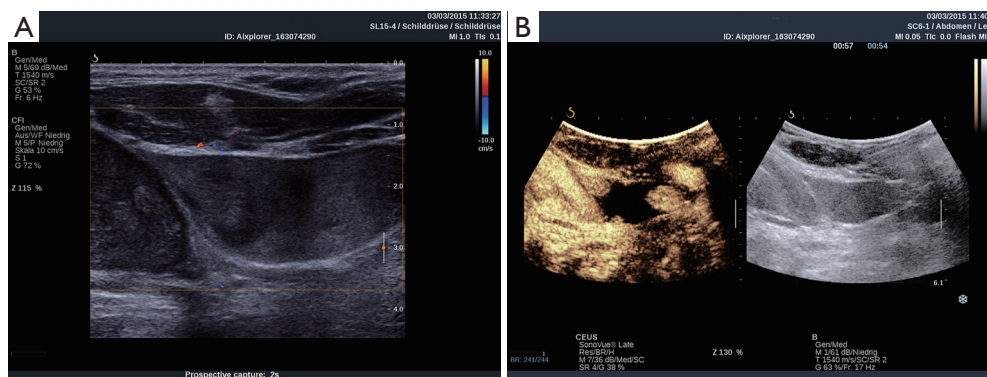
Difficult venous access due to a hypoechoic tumor (Schwannoma). (A) B-mode US; (B) delineation of the tumor and the target vessel using CEUS. US, ultrasound; CEUS, contrast-enhanced US.
